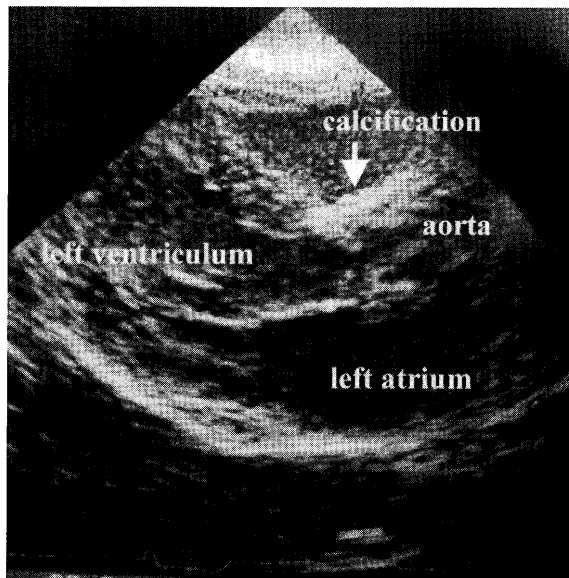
Echocardiography reveals calcification of the aortic valve up to ascending aorta
